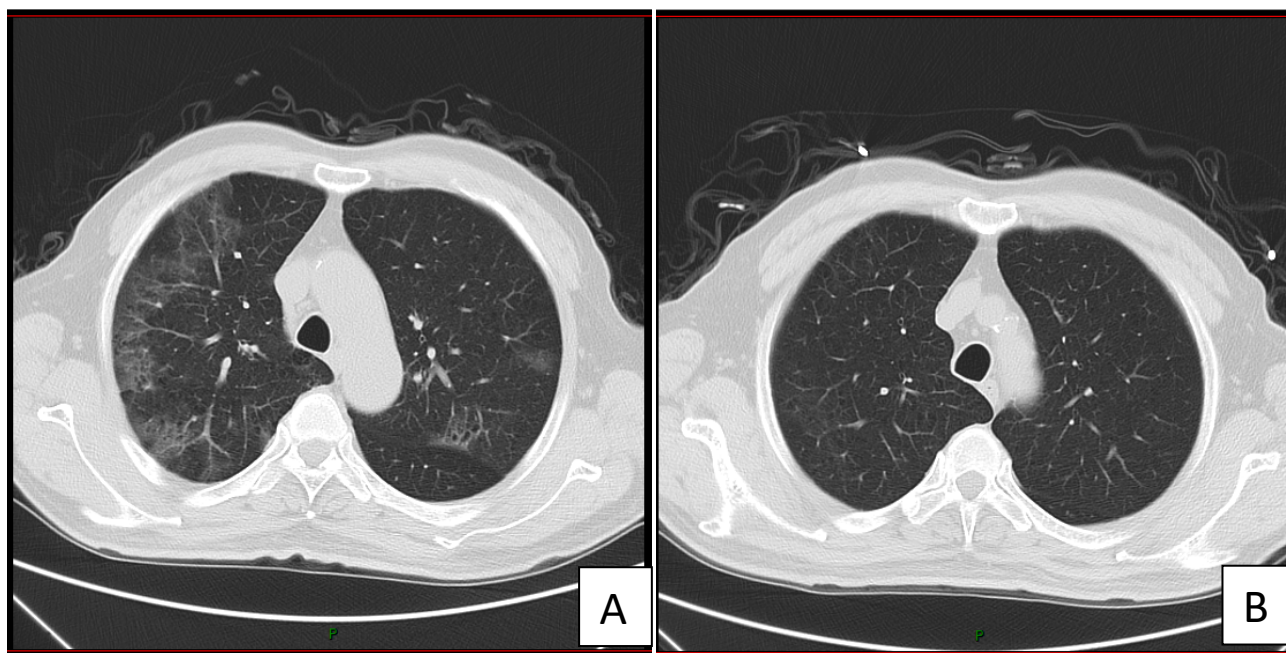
CT changes in the lung after treatment in case 1 patient with covid-19. A. On February 13, the first CT examination after hospitalization showed multiple patchy ground glass opacity; B. on April 6, after treatment, the scope of bilateral lung lesions was significantly reduced and the inflammation was absorbed.
